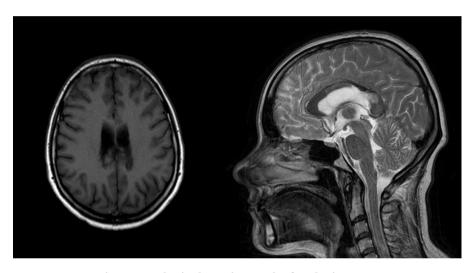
MRI brain done six month after the impact.
